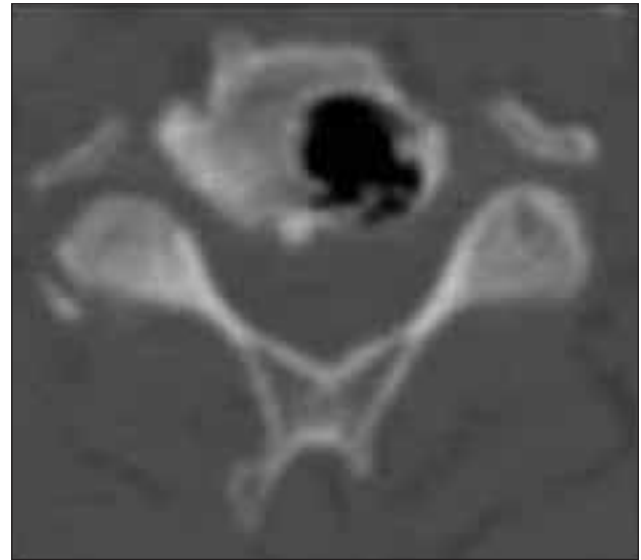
Axial section of cervical vertebrae CT showing pneumatocyst in the body of C4 vertebra.
